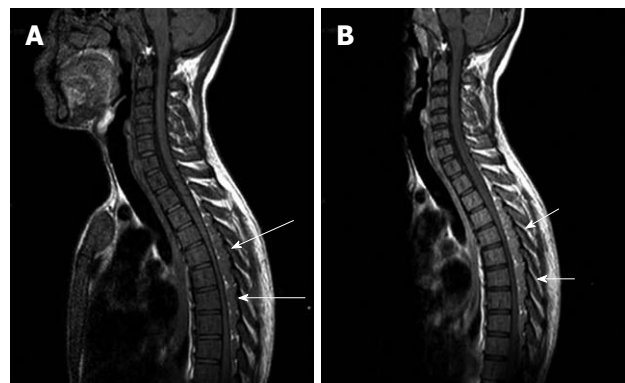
Preoperative sagittal magnetic resonance imaging, T1 weighted, without contrast media (A) (long arrows), and after Gadolinium administration (B) (short arrows) shows poor and homogeneous contrast enhancement of the masses.
